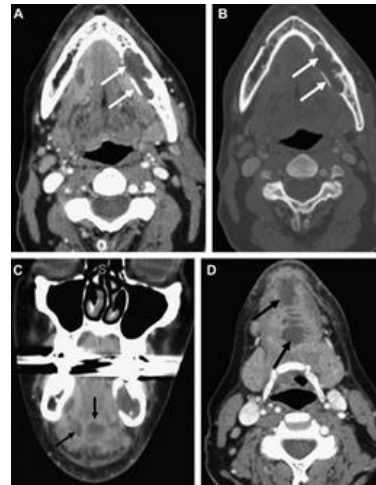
Ludwig's odontogenic infection-related angina. An enormous lytic region with irregular edges in the left mandible (white arrows) and concomitant widespread inflammatory changes (cellulitis) involving the floor of the mouth are shown on axial and coronal postcontrast CT scans of a 38-year-old male with severe odynophagia. Black arrows indicate areas of peripheral augmentation and central hypodensity in the oral tongue and floor of the mouth.
